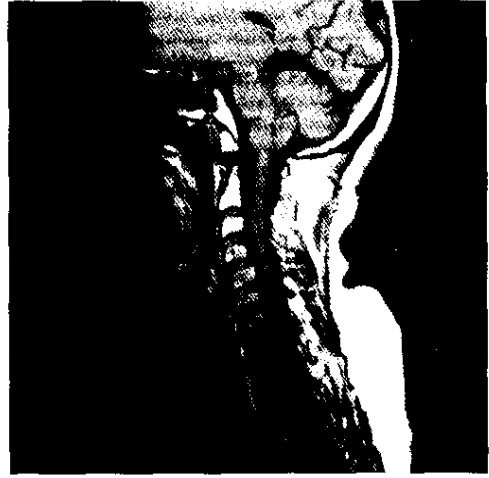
Sagittal cervical MRI showing a haemangioma involving the body and the dense complex of the axis of C2 vertebra
